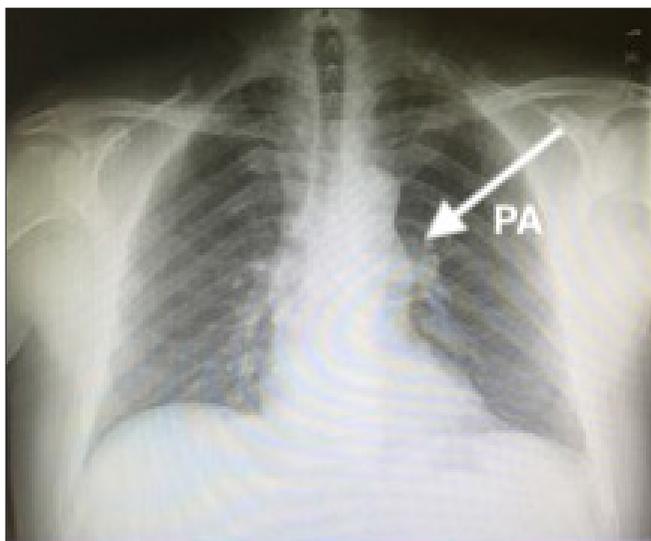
Chest X-ray showing the PA aneurysm
